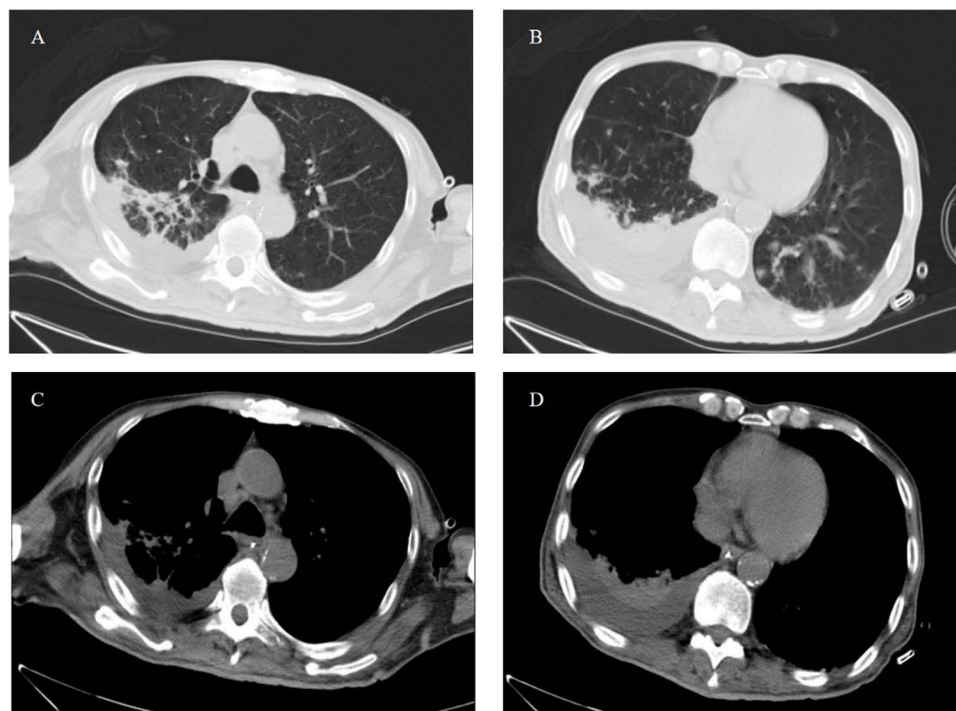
Chest computed tomography scan shows right lower lobe infiltration (A, C) with pleural effusion (B, D) at the initial hospital presentation. (A and B) are the lung window, and (C and D) are the mediastinal window.
